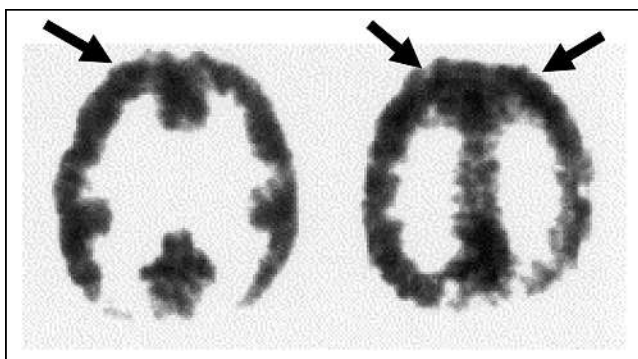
Eight-year-old girl with Rett syndrome whose ^{18}F -FDG PET scan shows bilateral frontal cortex hypermetabolism (arrows). (Reprinted with permission from Elsevier (14).)
